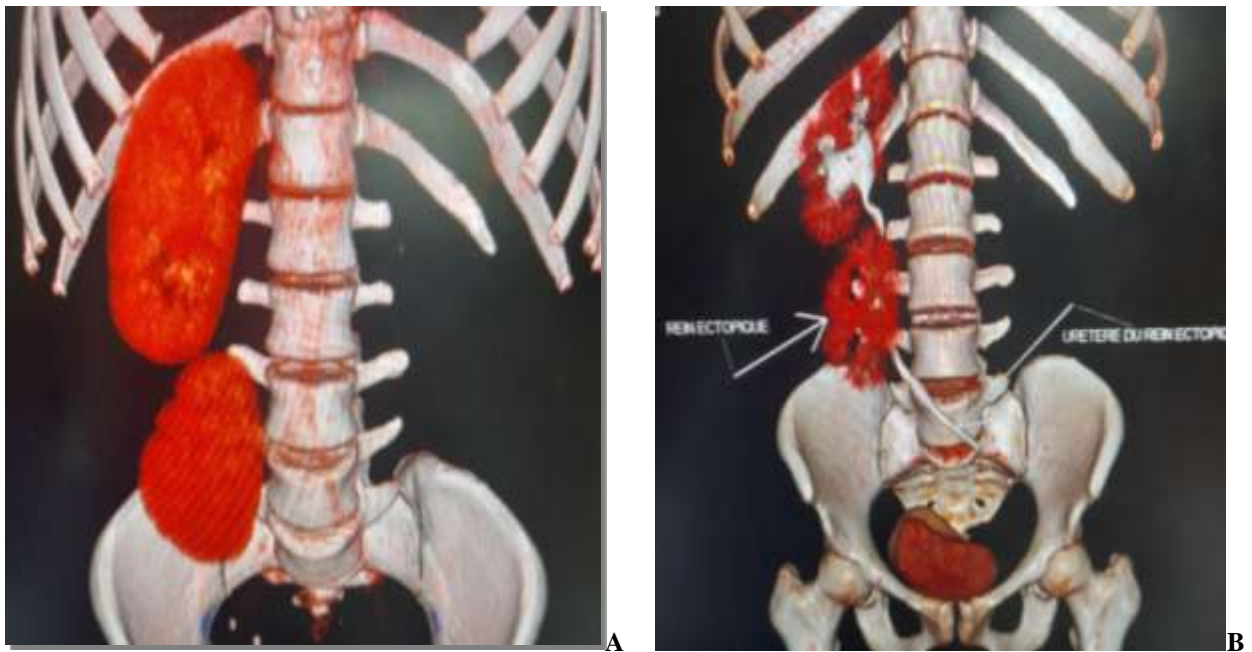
(A and B):- Abdominal ultrasound showing an empty left lumbar fossa and an ectopic kidney sitting in the right iliac fossa.
